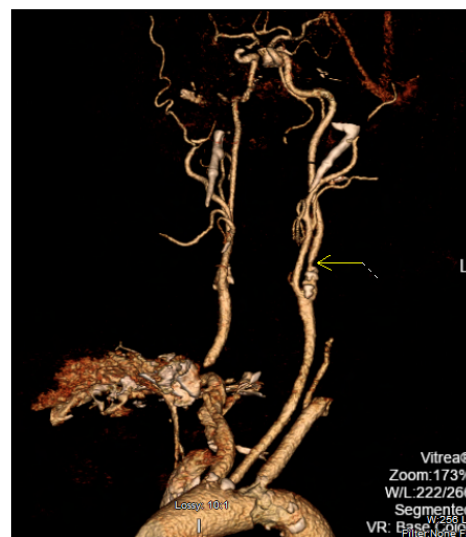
CTA 3-D rendering of bilateral carotid arteries
